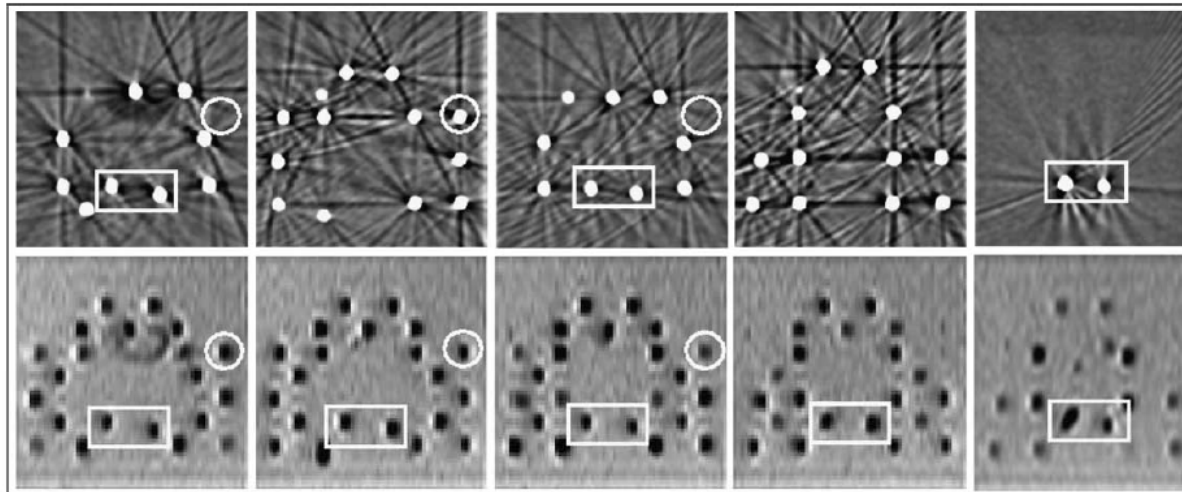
Five consecutive slices for CT (Siemens) and MRI (Philips 1.5T) taken with 5 mm slice thickness. MR images are displayed below the corresponding CT slices. For the same geometry, more seed signal voids are visible on MRI than CT. Some examples are marked with a circle and rectangle.
